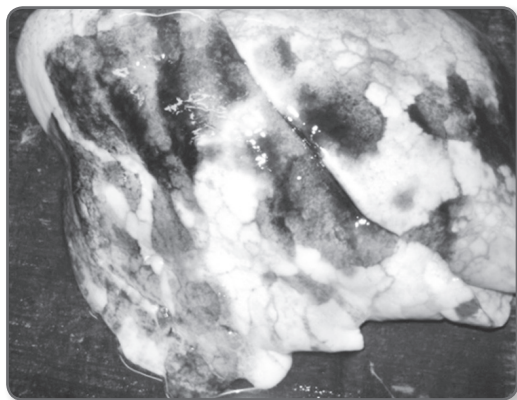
Lung – Inhalation of sulfuric acid; note: There are alternative areas of bleeding (Corrosion and rupture of arteries) and pale lung parenchyma – A treated case died after 20 days of poisoning near the recovery period; CT could not pick up the lung finding and the patient suddenly collapsed after a heavy bout of haemoptysis.
